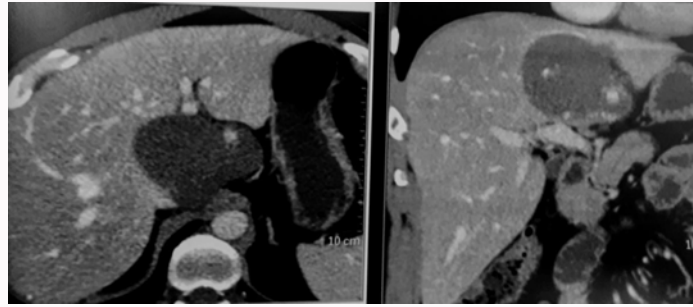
Preoperative Contrast-enhanced CT- Large HH in Caudate Lobe.
